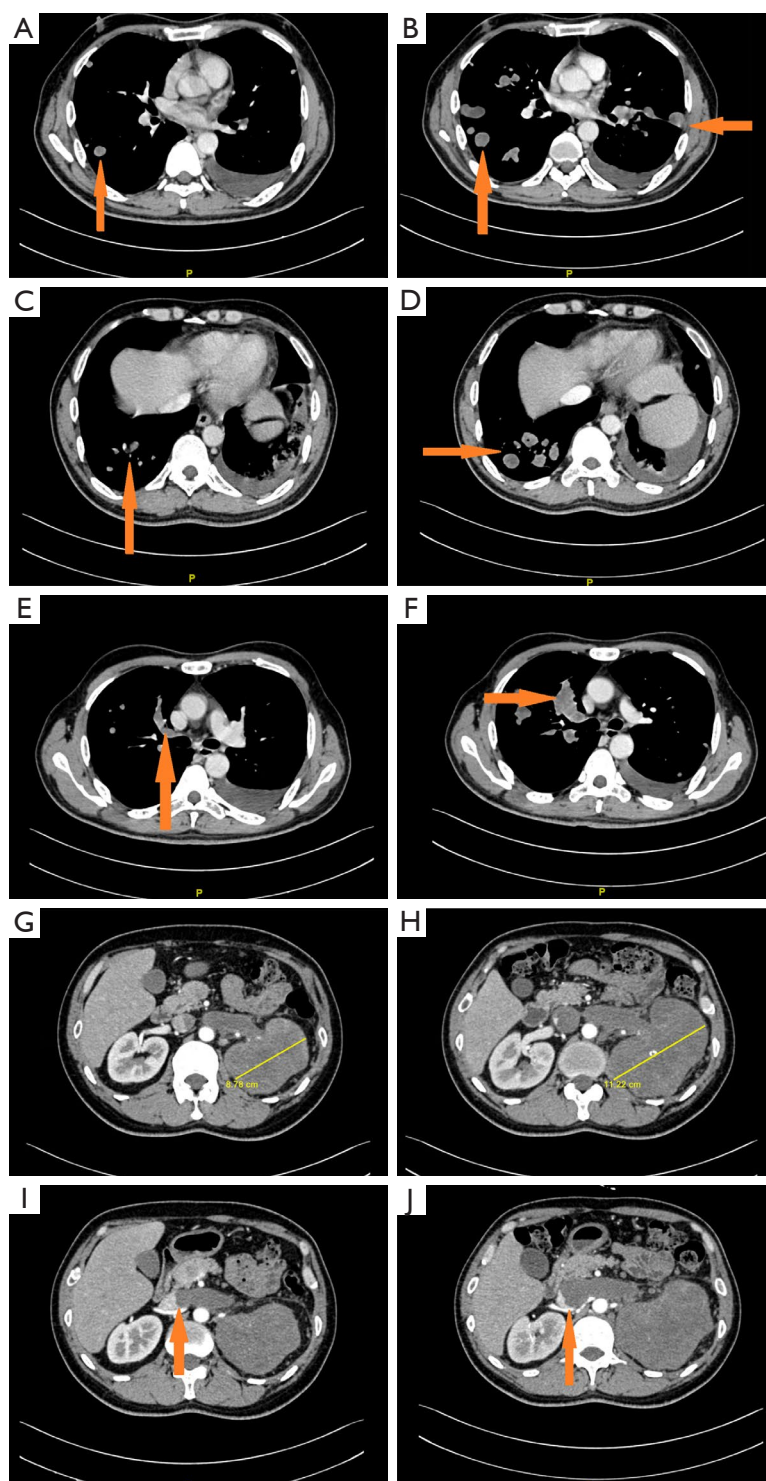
CT imagings of the patient's lungs and kidneys at the initial visit and a month later. Orange arrows indicate (A,C) lung metastases, (E) a pulmonary artery cancerous embolus, and (I) a renal vein cancerous embolus at the time of initial diagnosis. One month later, orange arrows indicate (B) new lung metastases on the left side, enlarged lung metastases on the right side, (D) enlarged lung metastases, the progression of the (F) pulmonary artery cancerous embolus and (J) renal vein cancerous embolus. The size of the patient's left renal lesion was (G) 8.78 cm at the initial diagnosis and (H) increased to 11.22 cm 1 month later. CT, computed tomography.
